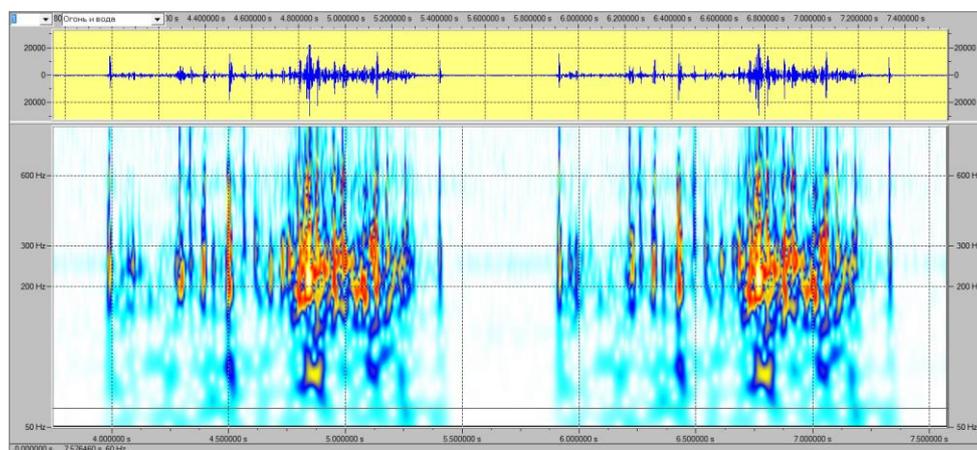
Acoustic sonogram of the sound of medium-bubbly wet wheezes. Frequency range 60-900 Hz
